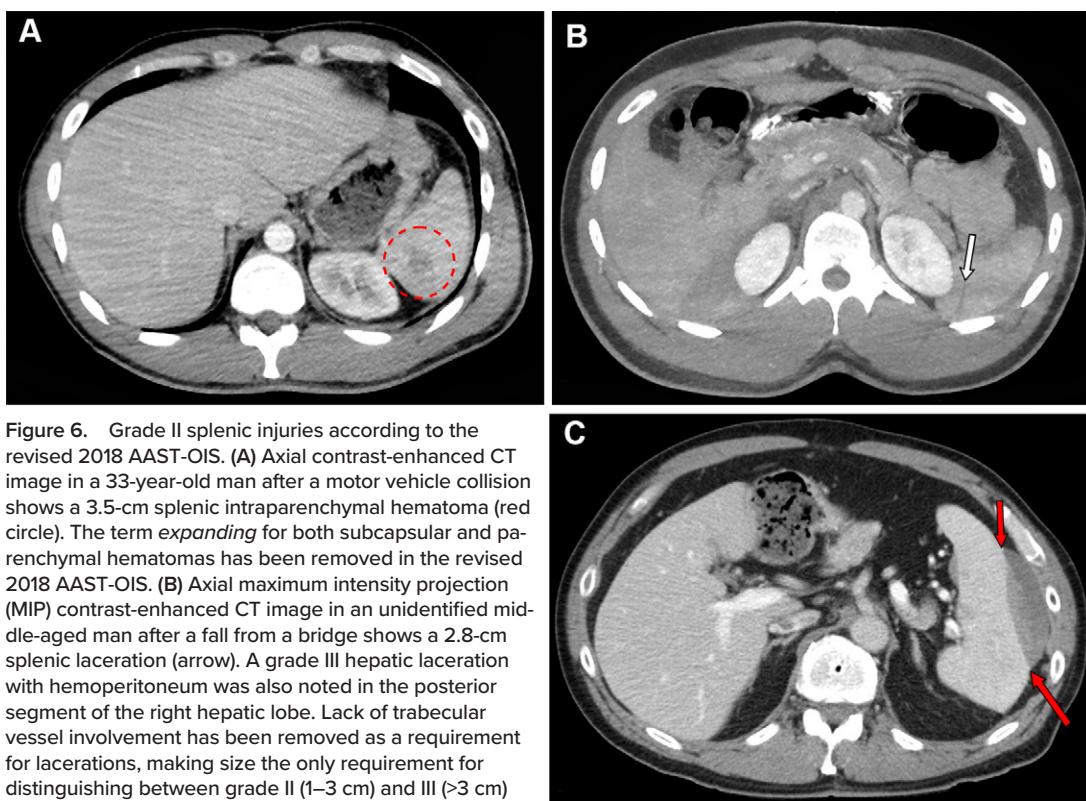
Grade II splenic injuries according to the revised 2018 AAST-OIS. (A) Axial contrast-enhanced CT image in a 33-year-old man after a motor vehicle collision shows a 3.5-cm splenic intraparenchymal hematoma (red circle). The term *expanding* for both subcapsular and parenchymal hematomas has been removed in the revised 2018 AAST-OIS. (B) Axial maximum intensity projection (MIP) contrast-enhanced CT image in an unidentified middle-aged man after a fall from a bridge shows a 2.8-cm splenic laceration (arrow). A grade III hepatic laceration with hemoperitoneum was also noted in the posterior segment of the right hepatic lobe. Lack of trabecular vessel involvement has been removed as a requirement for lacerations, making size the only requirement for distinguishing between grade II (1–3 cm) and III (>3 cm) injuries in the revised 2018 AAST-OIS version. (C) Axial contrast-enhanced CT image in a 39-year-old man after a motorcycle crash shows a subcapsular hematoma (arrows) spanning approximately 30% of the splenic surface area. An axial cine clip of this patient is shown in Movie 2.
